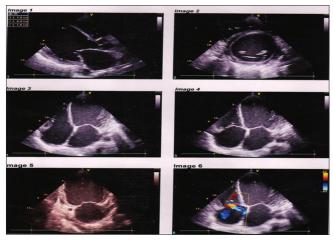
Echocardiogram 2 weeks before admission
